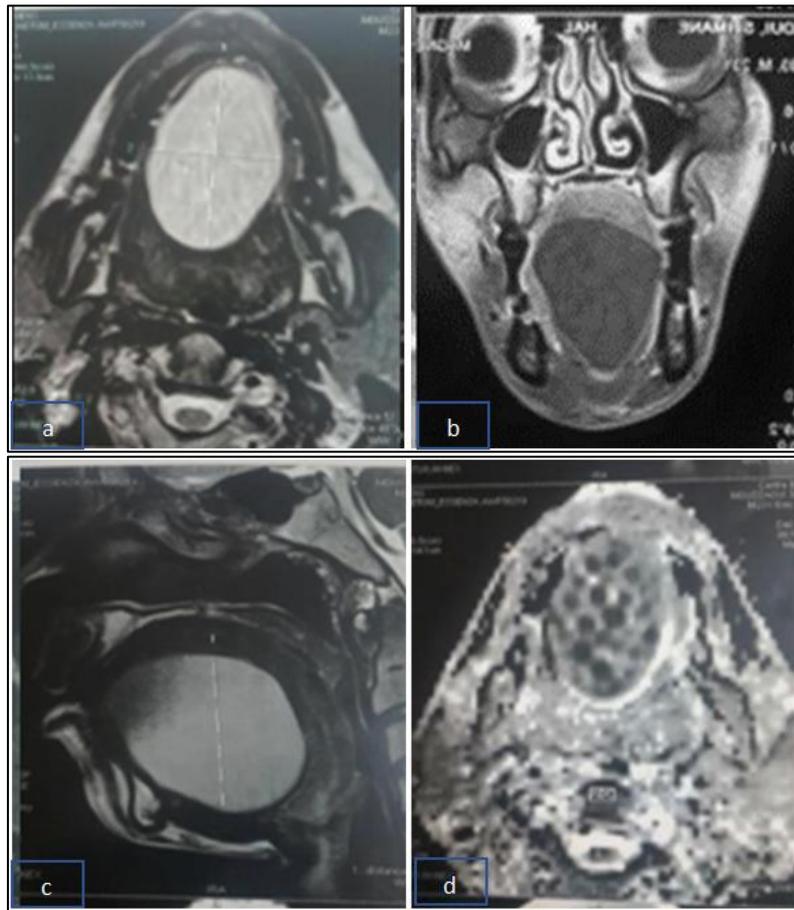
(MRI of the face): a rounded, homogeneous, fluid-filled, multi-vesicular, sublingual mass measuring 54 mm in width, surrounded by a thin wall with no elevation and no infiltration of neighbouring structures, suggestive of a hydatid cyst
